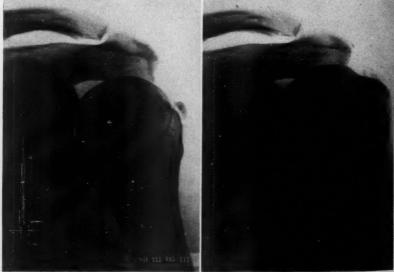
Case 1. Small calcification in the subdeltoid bursa. Symptoms relieved with X-ray therapy.
